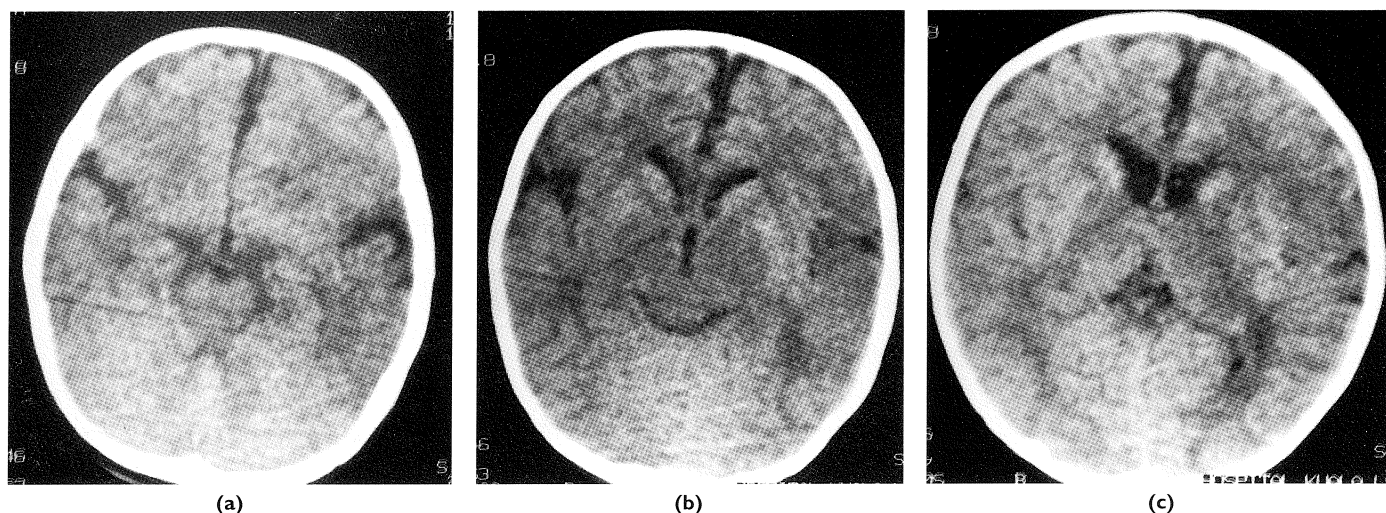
The computed tomography of the brain 6 months later showed that the oedema had resolved (a), (b) and (c). Widening of the cerebrospinal fluid spaces in (b) indicates loss of brain substance.
